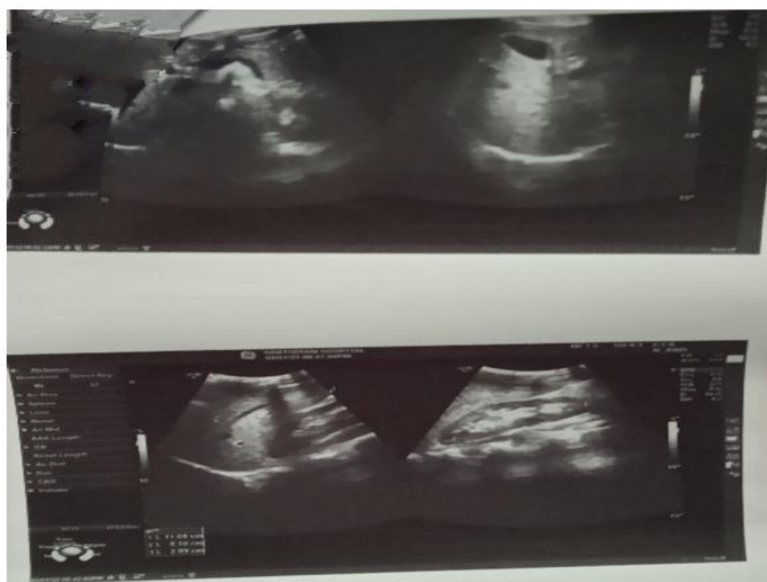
Ultrasound scan of abdomen
